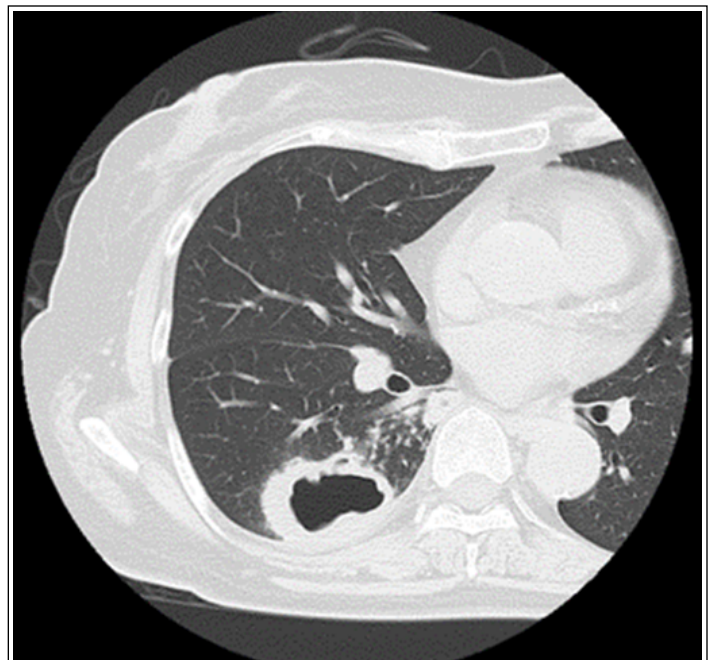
Chest CT scan: A thick walled cavitated lesion measuring 50 mm is seen subpleurally in the S6 segment of the right lung.
